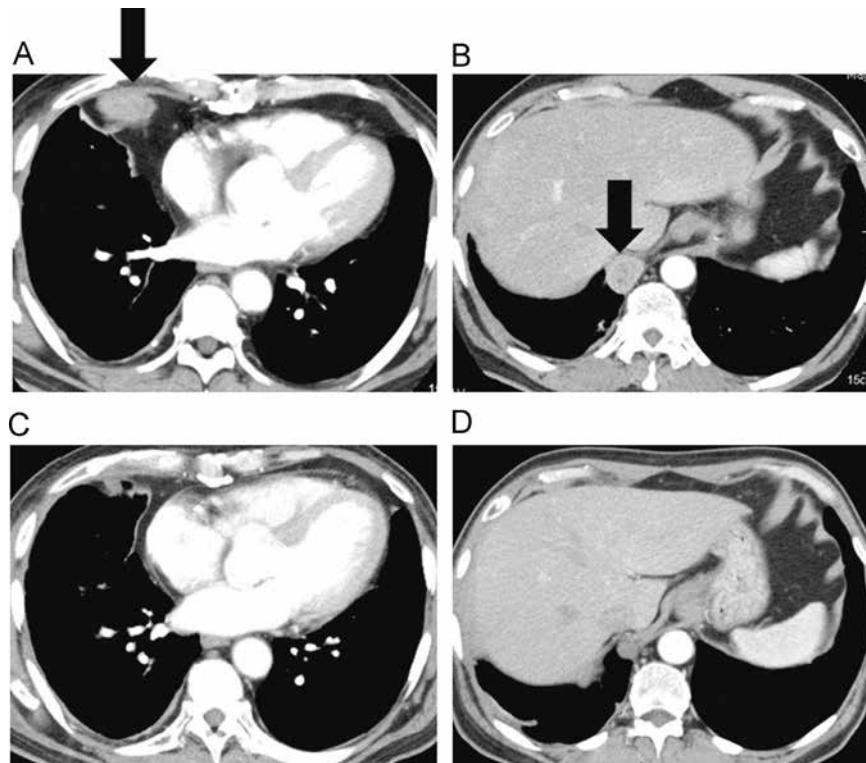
Computed tomography images at diagnosis (A, B) and after the 6 cycles of systemic chemotherapy consisting of cisplatin and pemetrexed (C, D). Black arrows indicate the tumors on the pleura.
